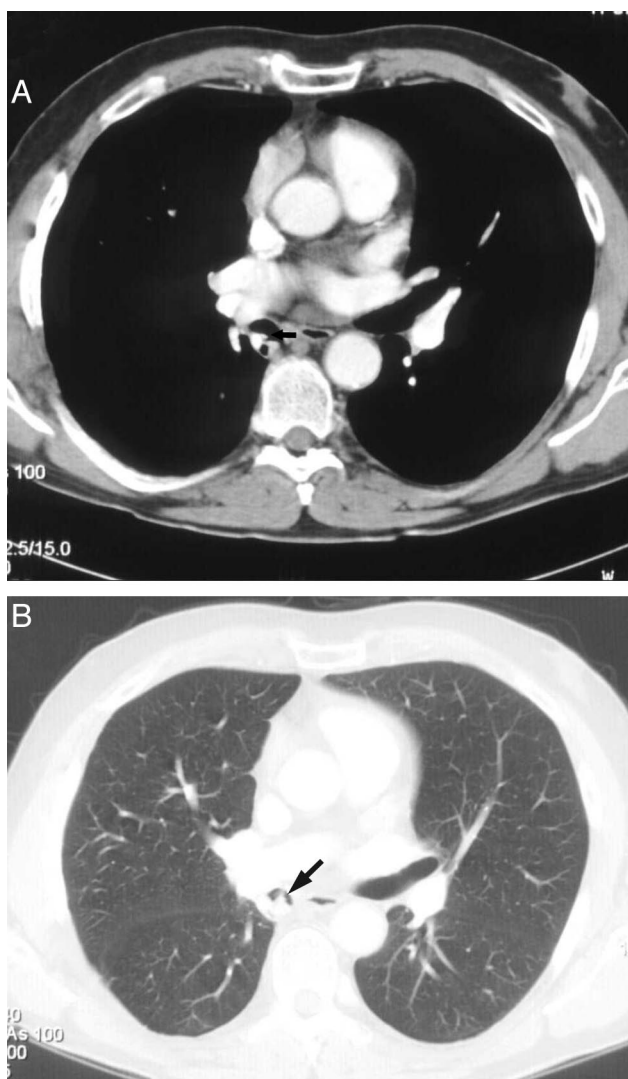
Computed tomogram shows a suspicious formation in the bronchus intermedius (arrow), without substantial mediastinal lymph node enlargement.
